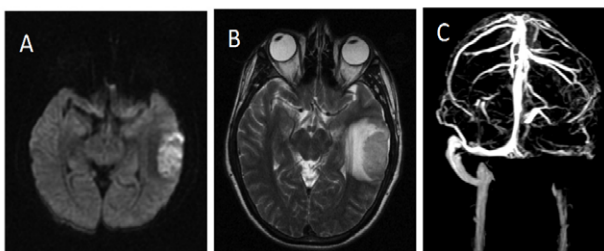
DWI (A) and T2 MRI (B) showing increased signal suggestive of ischemic lesions. (C) MRI venography showing decrease signal of the left transverse and sigmoid sinuses suggestive of venous thrombosis.
